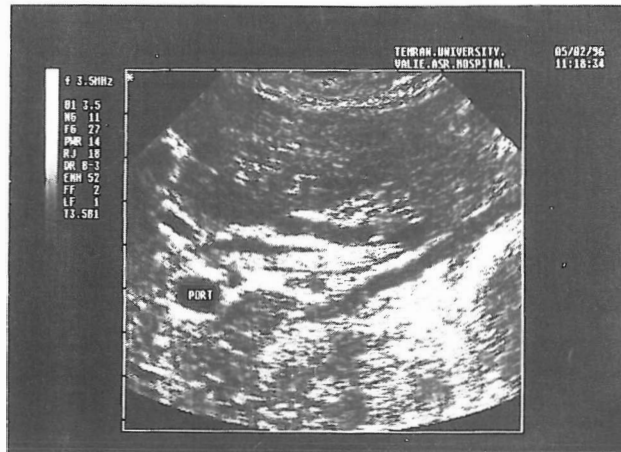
Ultrasound of porta hepatis in plane of CBD shows the parasite within the duct.
